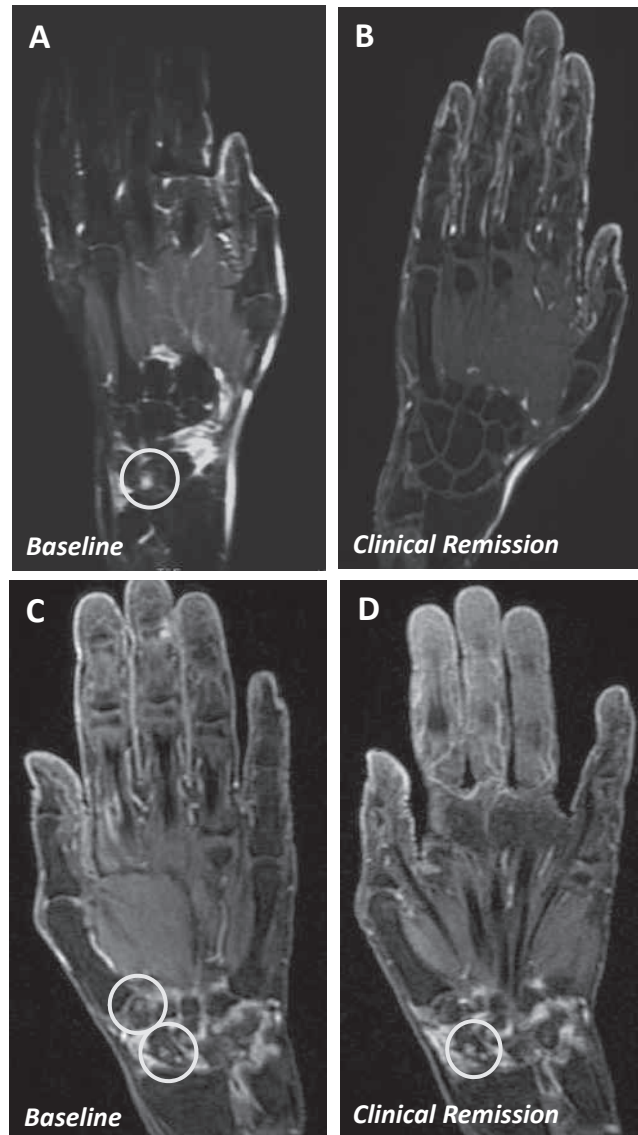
Bone edema of MRI imaging in patients with rheumatoid arthritis receiving biologics (A and B) or nonbiologics (C and D). At baseline, high-signal intensity on T2-weighted images (open circle), consistent with bone edema, was observed in both patient treated with IFX (A) and FK506 (C). At clinical remission, the high-signal intensity disappeared in a patient treated with IFX (B). On the other hand, the high-signal intensity of bone edema were detected in a patients treated with FK506 (D).
